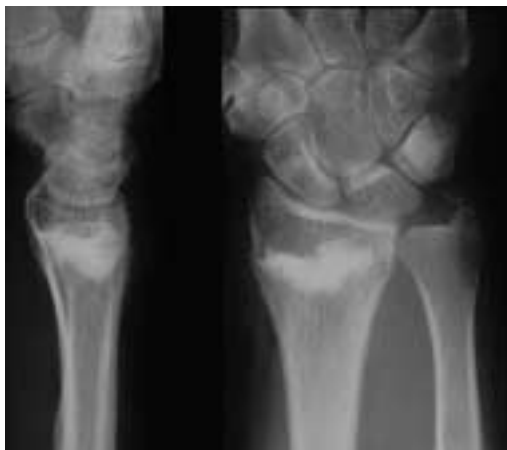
X-ray of radius with Norian SRS in situ.
